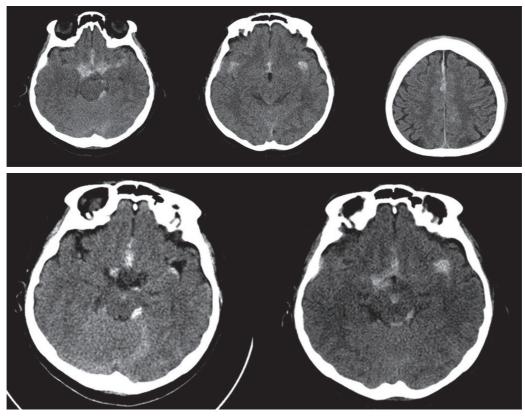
Brain computed tomography (CT); Diffuse subarachnoid hemorrhage (SAH) on basal cistern and bilateral sylvian fissure, subdural hemorrhage (SDH) around falx were identified. Subarachnoid hemorrhage also noted in the interpeducular, left ambient and quadrigeminal cisterns.
